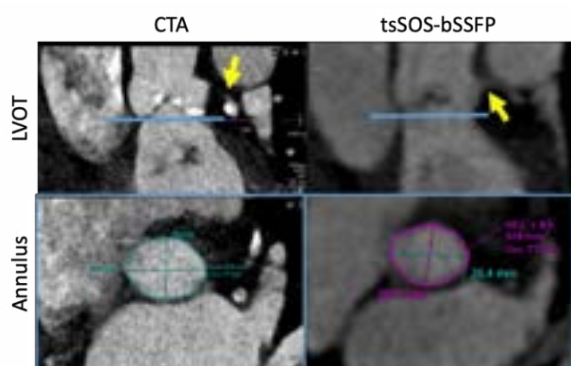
Left ventricular outflow tract (LVOT) and annulus views of TAVR planning CTA and tsSOS-bSSFP showing comparable image quality. Blue line: annular plane, yellow arrow: left main coronary artery
